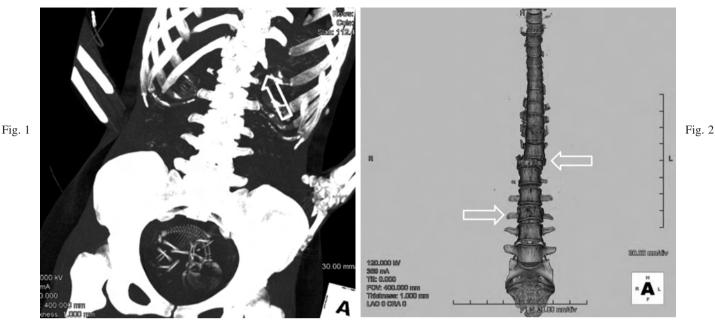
Helical computed tomographic scanning with MRP showing a fetus in utero. Th12 fracture is suspected (*open arrow*). Figure 2. — Helical computed tomographic scanning with 3D-rendering showing burst fractures on Th12 and L3 (*open arrow*).
